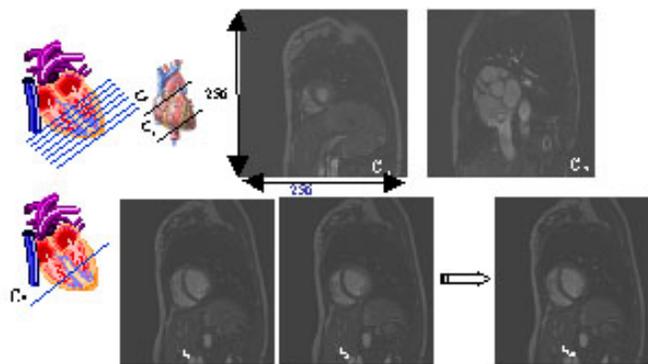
MRI acquisition composed of 7 short axis slice levels and 30 cardiac phases at each level.
